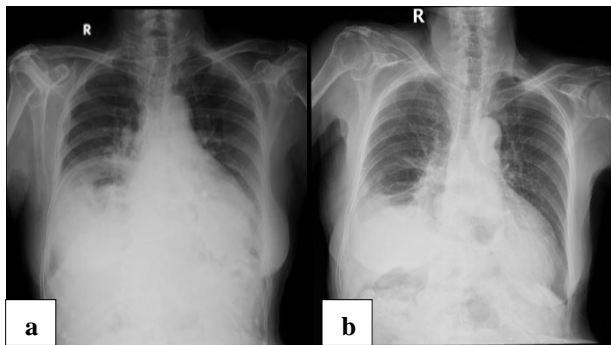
Posteroanterior and lateral chest X-ray images in a patient (a) preoperative and (b) postoperative.
